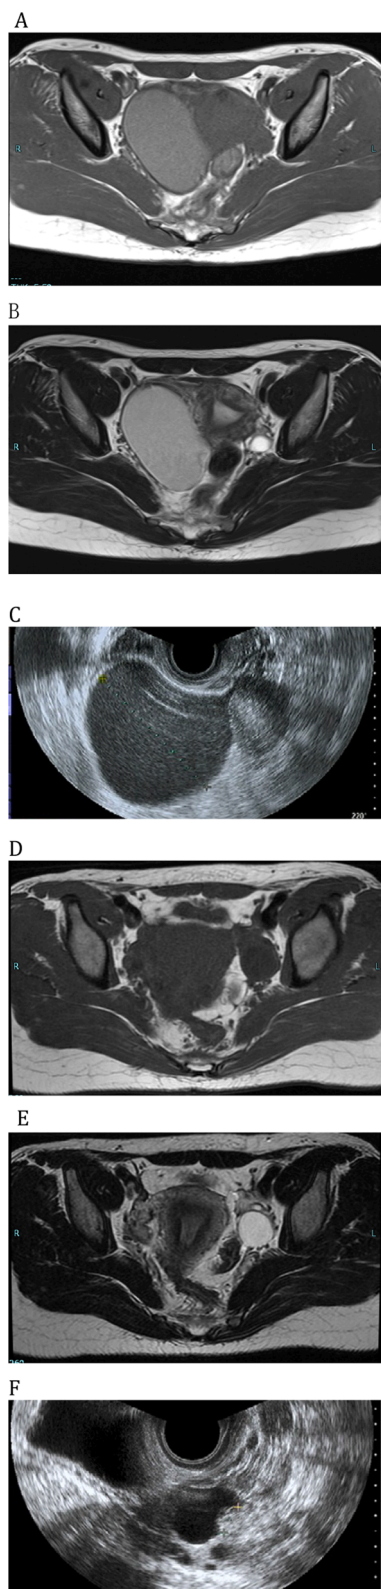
(A–C) Images taken before the initial treatment: MRI T1 (A) shows a slightly high intensity monolocular 8.5-cm right ovarian cyst, MRI T2 (B) shows high intensity, and the transvaginal ultrasound scan (C) shows no nodules in an ovarian cyst. (D–F) Images of relapse, MRI T1 (D) shows a low intensity 3-cm right ovarian simple cyst, MRI T2 (E) shows high intensity, and the transvaginal ultrasound scan (F) shows 5-mm nodules in an ovarian cyst.
